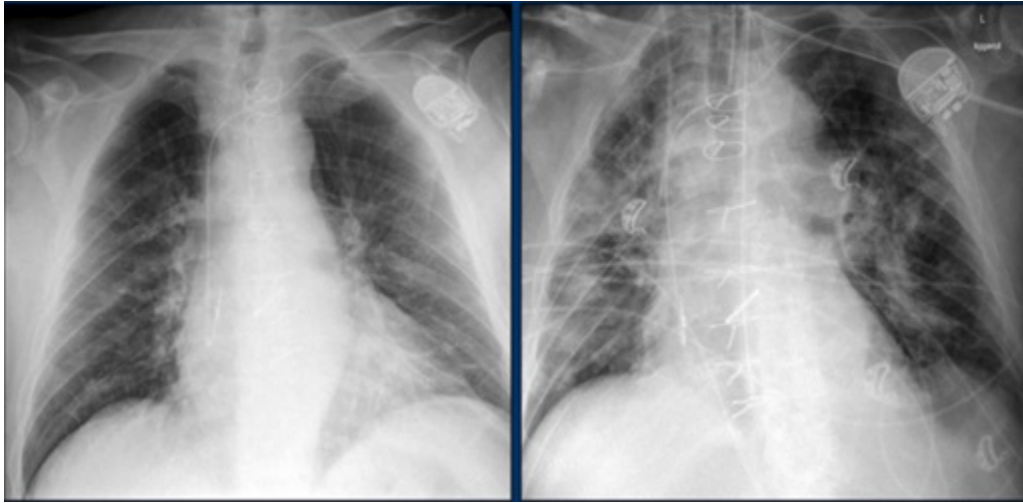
On the radiography of the patient diagnosed with COVID-19, who is 83 years old with known heart failure, pulmonary hypertension and atrial fibrillation, ground glass opacities and consolidation are seen in the right upper lobe and lower left lobe.
